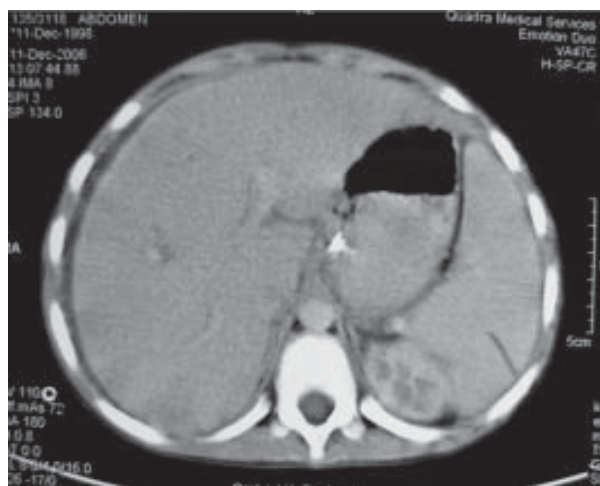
CT scan of abdomen showing splenic rupture.
